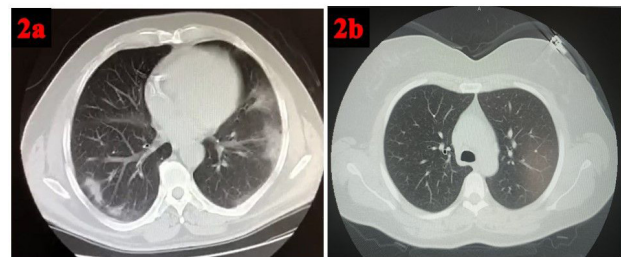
Axial CT images of a 60-year-old patient with a positive rRT-qPCR test result. Ground-glass opacities located in the lower lobes of both lungs and the left lung lingular segments. 2b; A 42-year-old woman with a positive rRT-qPCR test result but negative CT findings has normal parenchymal images.
